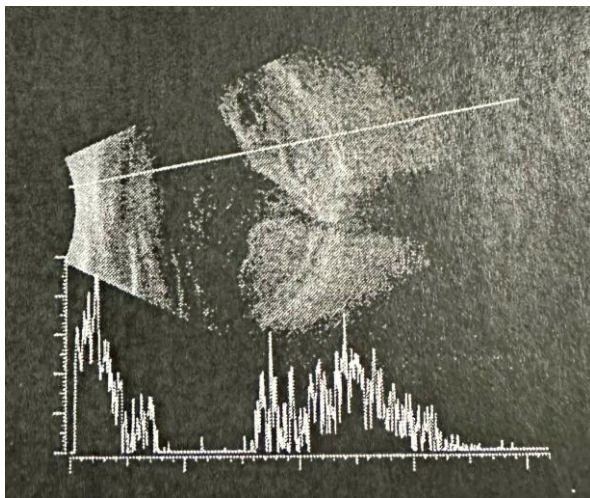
Ultrasound examination, image corresponding to hemorrhagic retinal detachment.
